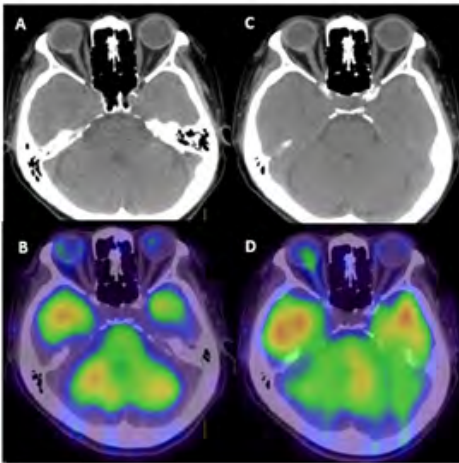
I-123 IMP SPECT/CT images of a 64-year-old woman, who was being followed for several years for a right choroidal nevus. (A, B) Images taken 6 months after the previous examination, indicating that the tumor had expanded slightly from 6.4 mm × 3.0 mm to 7.5 mm × 3.0 mm, together with pigmentation. I-123 IMP SPECT/CT accumulation increased from 1.15 to 1.29 in parameter C, in which the cutoff value was 1.14. Although the CT image remained stable, this suggested malignant transformation.
